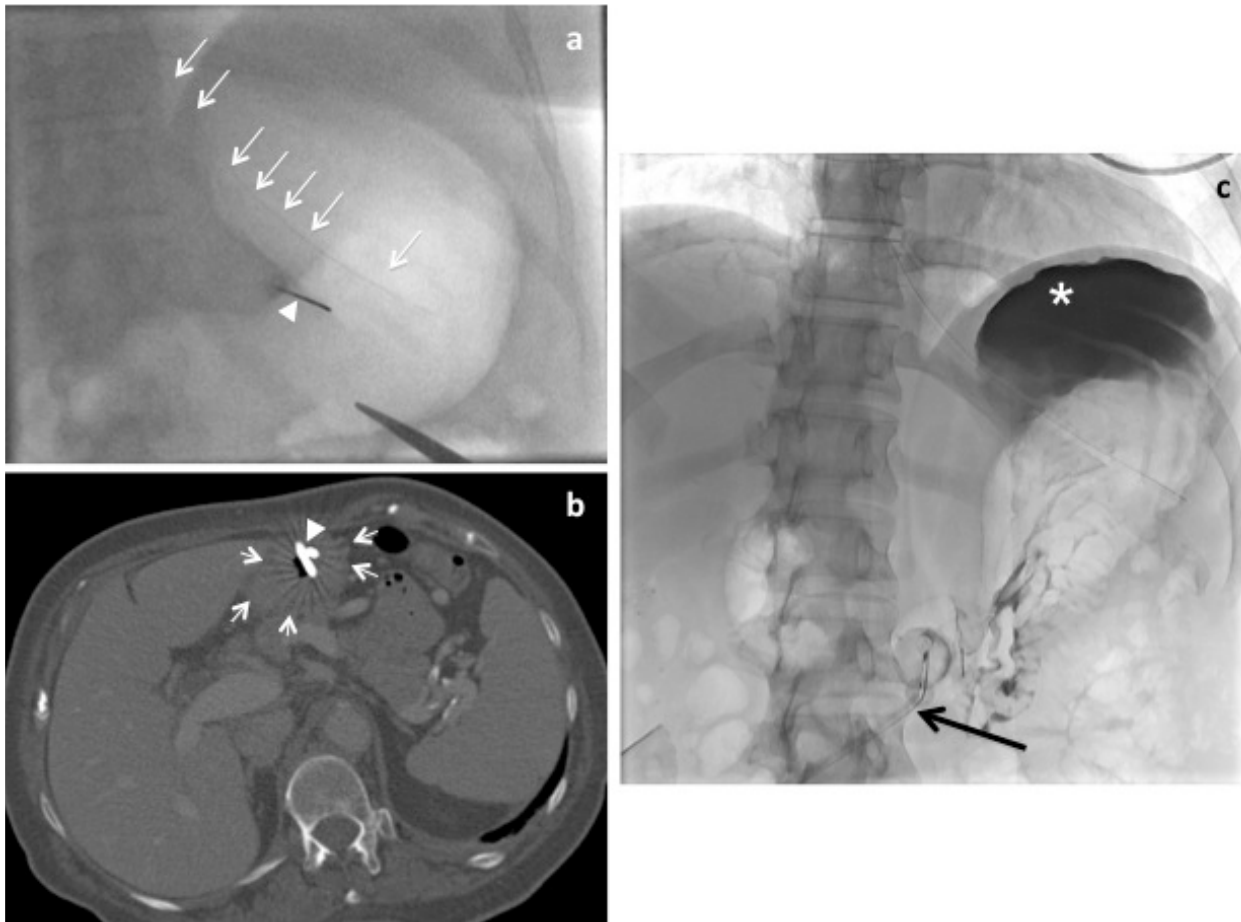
Gastrostomy. (a) Fluoroscopic image of stomach insufflated with gas via an nasogastric tube (*white arrows*), displacing adjacent bowel loops and facilitating visualization of the stomach to allow safe puncture with a needle (*arrowhead*). (b) Axial CT image shows correct placement of gastrostomy tube (*arrowhead*) within the stomach (outlined by *white thin arrows*). (c) Fluoroscopic image of stomach following gastrostomy placement (*black arrow*). Radio-opaque contrast is injected through the gastrostomy to ensure no intraperitoneal leak occurs. Contrast material in stomach is demonstrated by a *white asterisk*.
